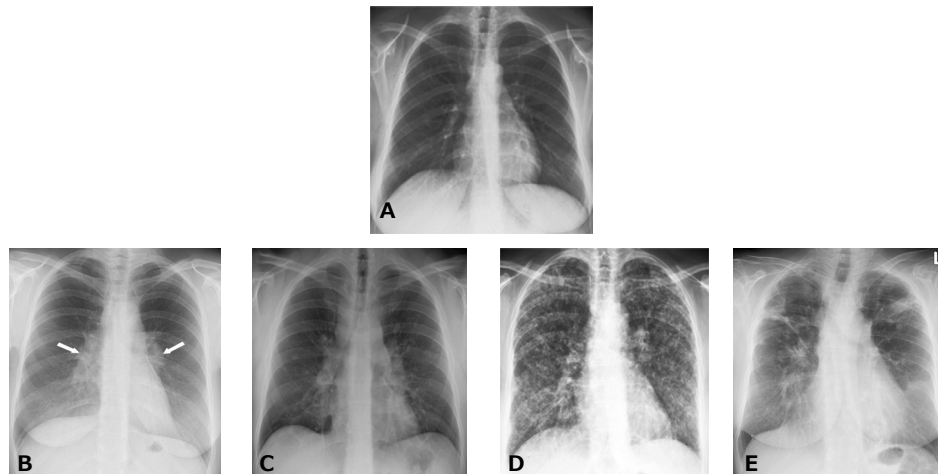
Chest X-ray (CXR) stages 0-IV: radiographic appearances of sarcoidosis. (A) Stage 0 (5-15%): normal chest radiograph; (B) Stage I (45-65%): bilateral hilar lymphadenopathy (arrows), without evidence of interstitial lung disease; (C) Stage II (30-40%): both lymphadenopathy and parenchymal abnormalities (nodular and reticulonodular opacities); (D) Stage III (10-15%): parenchymal infiltration without hilar lymph node enlargement (reticulonodular infiltrates); (E) Stage IV (15-25%): obvious interstitial abnormalities with fibrotic lesions.
